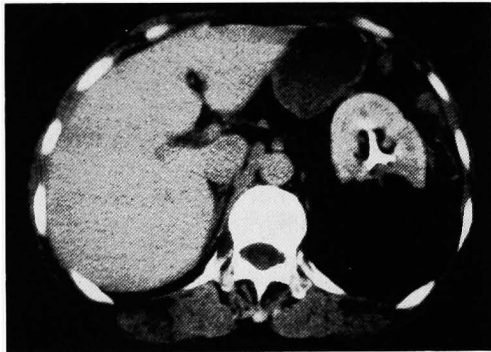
CT scan revealed a uniformly low density mass emerging from the left kidney.
